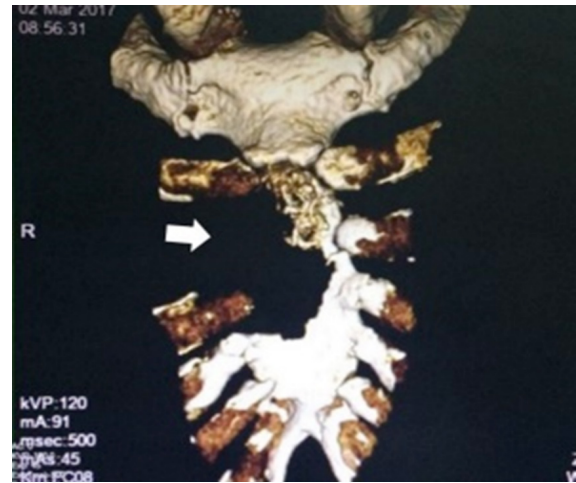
3D reconstruction of CT of thorax showing an aggressive lesion of sternum (white arrow)
